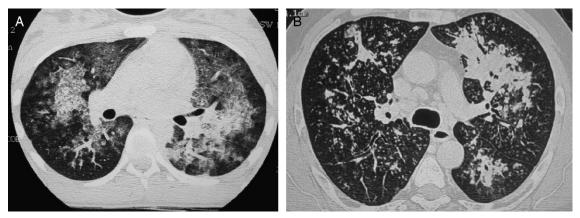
High-resolution computed tomography of alveolar hemorrhage in anti-basement membrane antibody disease. A. Diffuse ground-glass opacities of varied density, and areas of consolidation with air bronchogram. B. Patchy parenchymal consolidation with air bronchogram, and an uncommon micronodular pattern with areas of confluency.
